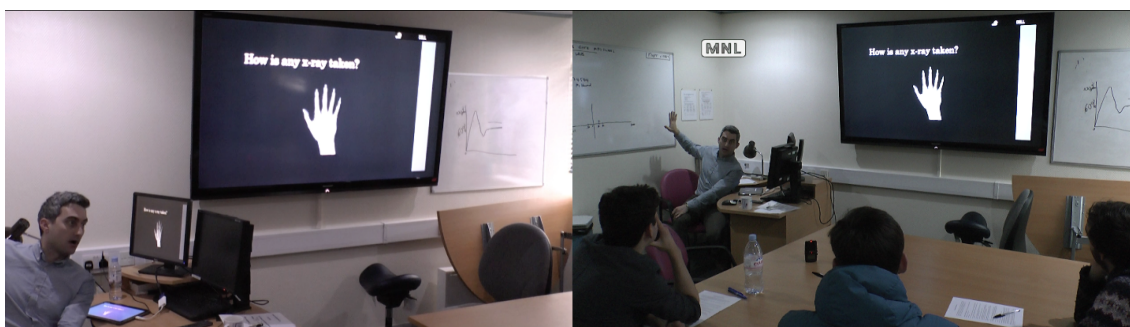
Dr. Saury's embodied multimodal performance for x-ray image production
